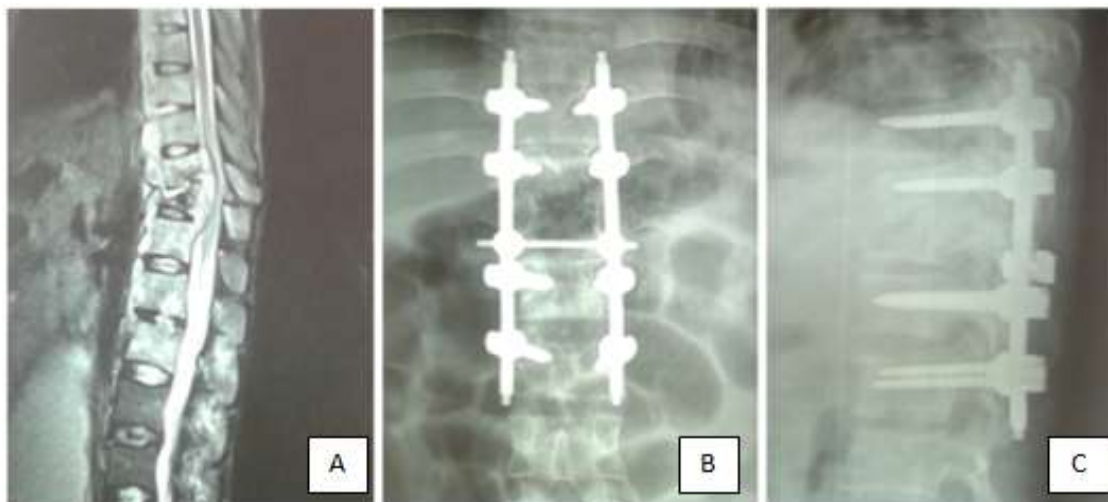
A- MRI showing Tuberculous involvement of D₉ to L₂ vertebrae with compression collapse of D_{10, 11} with multiple abscess. B and C- Antero-posterior and lateral view respectively, of dorso-lumbar spine with long segment pedicle screw extending from D₉ to L₁.
